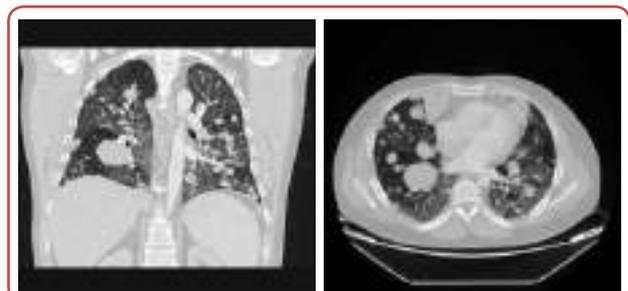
Chest computerised tomography (CT) scan after six cycles of chemotherapy
